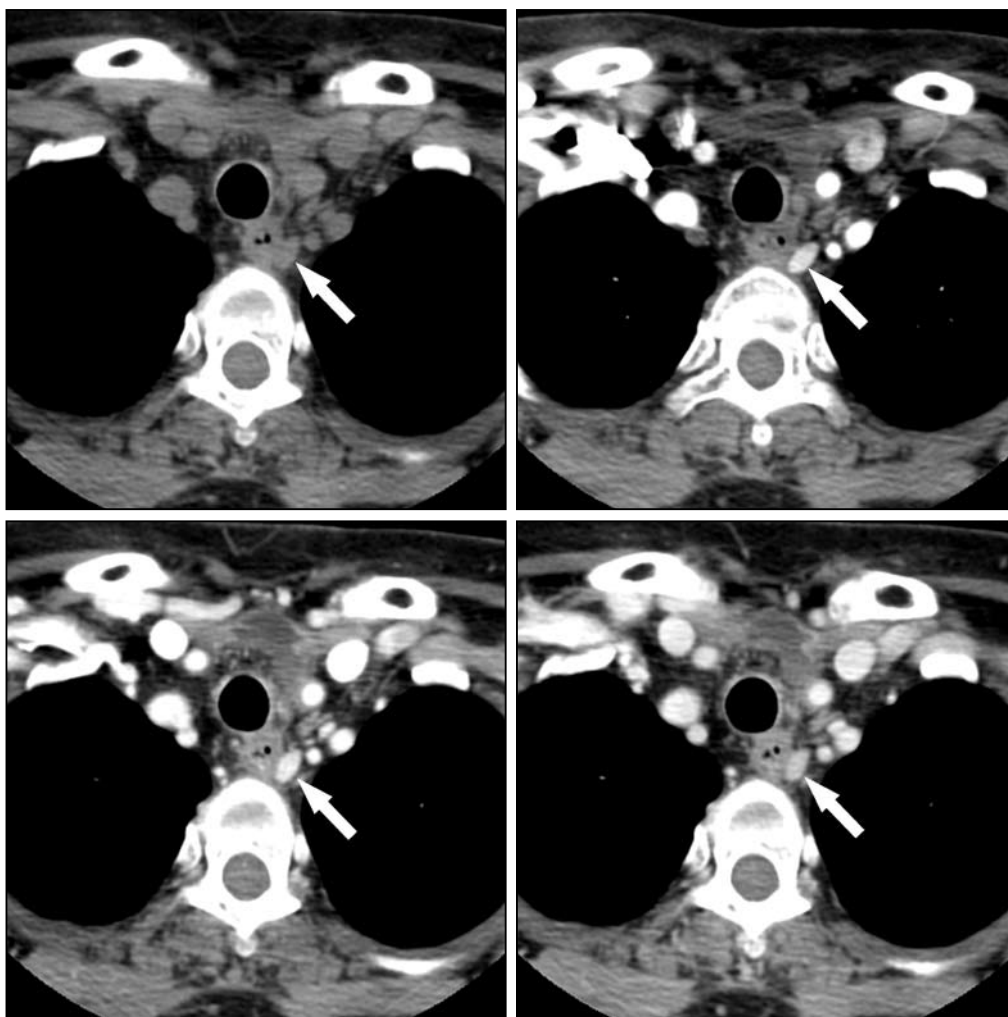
Axial CT examination (a. upper left) before, (b. upper right) 30 seconds, (c. lower left) 60 seconds and (d. lower right) 90 seconds after intravenous contrast administration demonstrate early arterial phase enhancement and washout of the ectopic parathyroid adenoma (arrows).
